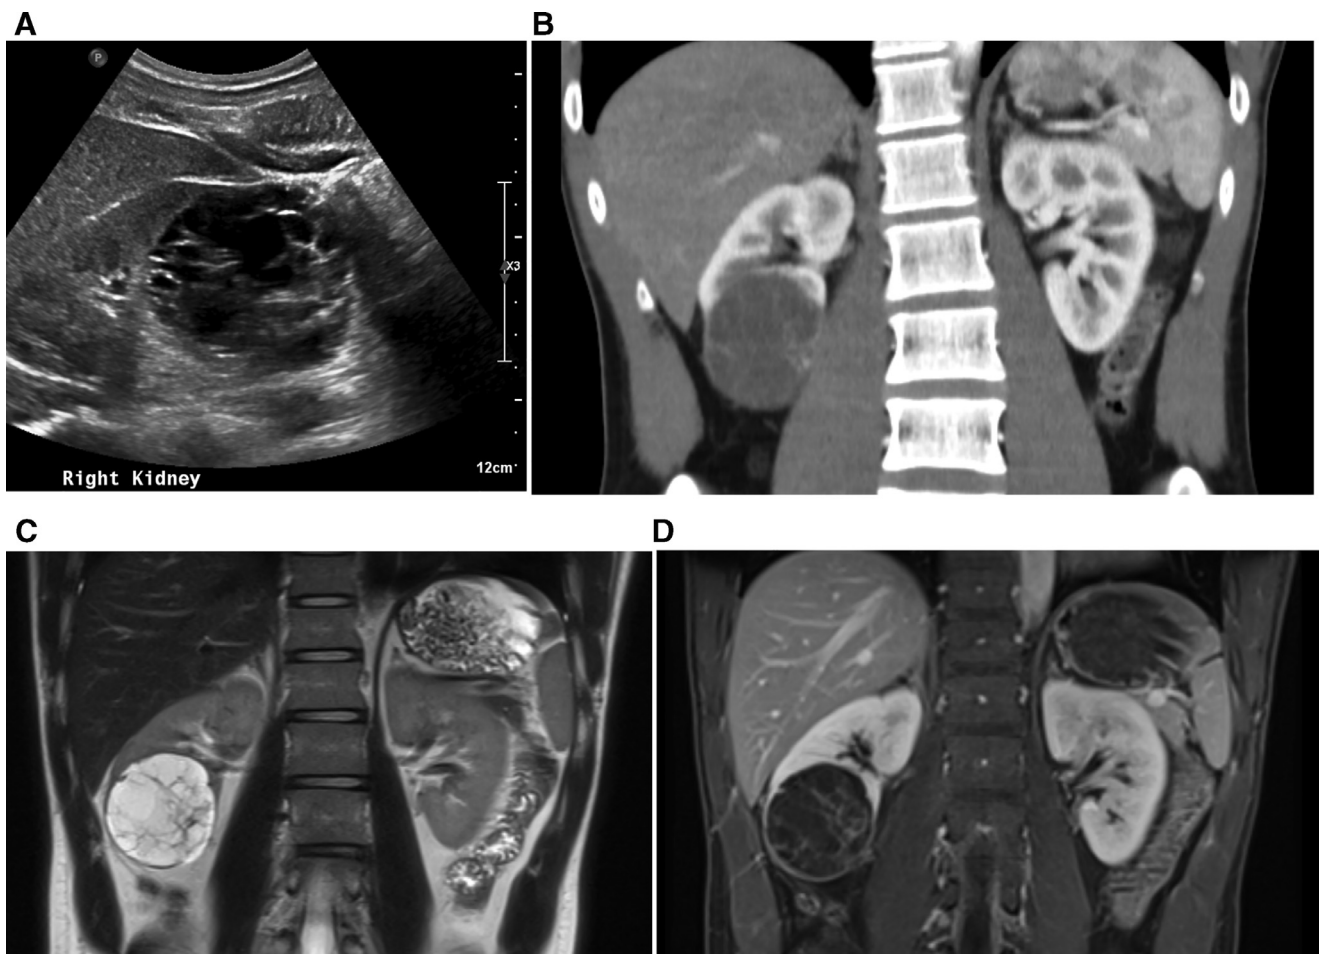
A 45-year-old female with an incidental right lower pole renal lesion. (a) US shows a multi-loculated cyst with many septations and some internal debris. (b) Similar findings are shown on coronal CT. (c) Coronal T2w and (d) Coronal post-contrast T1w fat-saturated MRI confirm a multiloculated cystic lesion. There is a low signal capsule around the lesion, suggestive of cystic nephroma. The patient opted for conservative management and the lesion has been stable on follow-up imaging.
